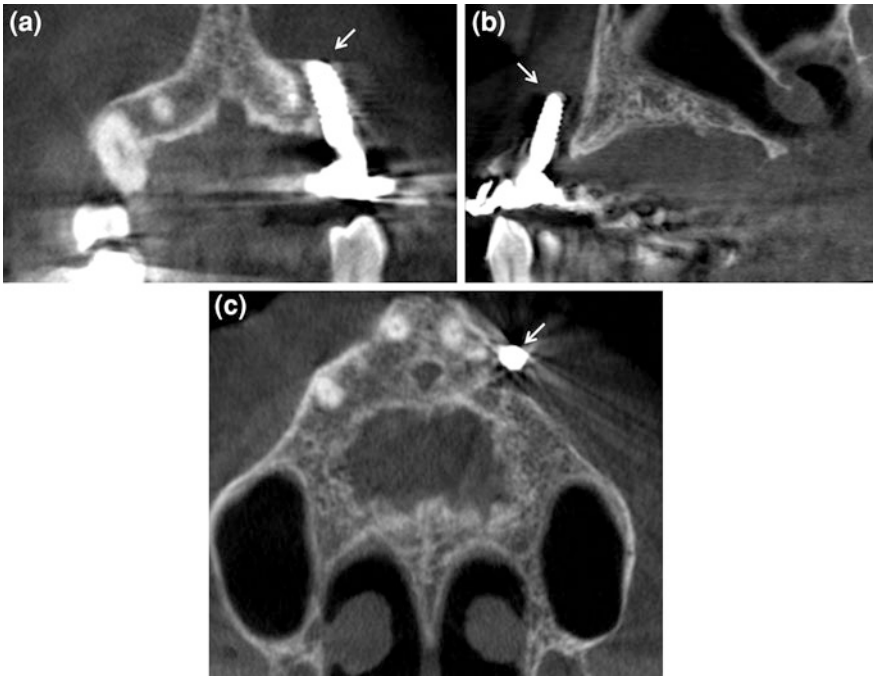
CBCT coronal (a), sagittal (b) and axial (c) scans showing clearly the implant screw (*thin arrow*) has lost the relationship with the alveolar bone and moves to vestibular side
